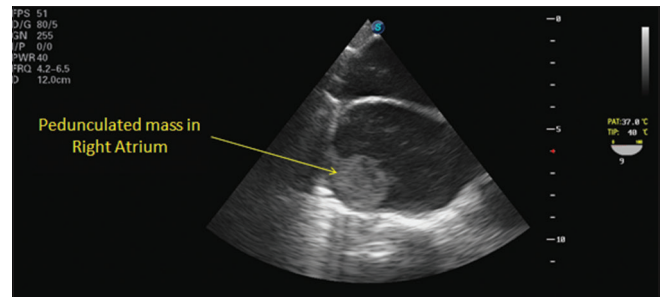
Transesophageal echocardiography view: Mid-esophageal 4 chamber view showing a pedunculated mass in right atrium
